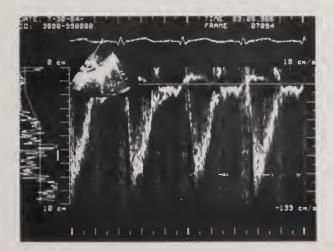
Is a freeze-frame (left upper insert) PWD flow trace with the SV placed in the main pulmonary artery (MPA) from the parasternal short-axis view. There is a negative (flow away from the scanhead) systolic flow below the zero baseline representing pulmonary forward flow. There is a presystolic "a" wave negative flow. Peak flow velocity (V) = 1.4 M/S.
